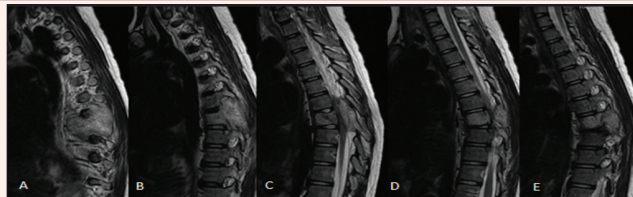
Magnetic resonance imaging of the thoracic spine in T2 in sagittal sections from left to right showing an expansive lesion centered on T8, further to the left, with destruction of the vertebral body, pedicles and spinous process at this level, extending to T7 and T9.
